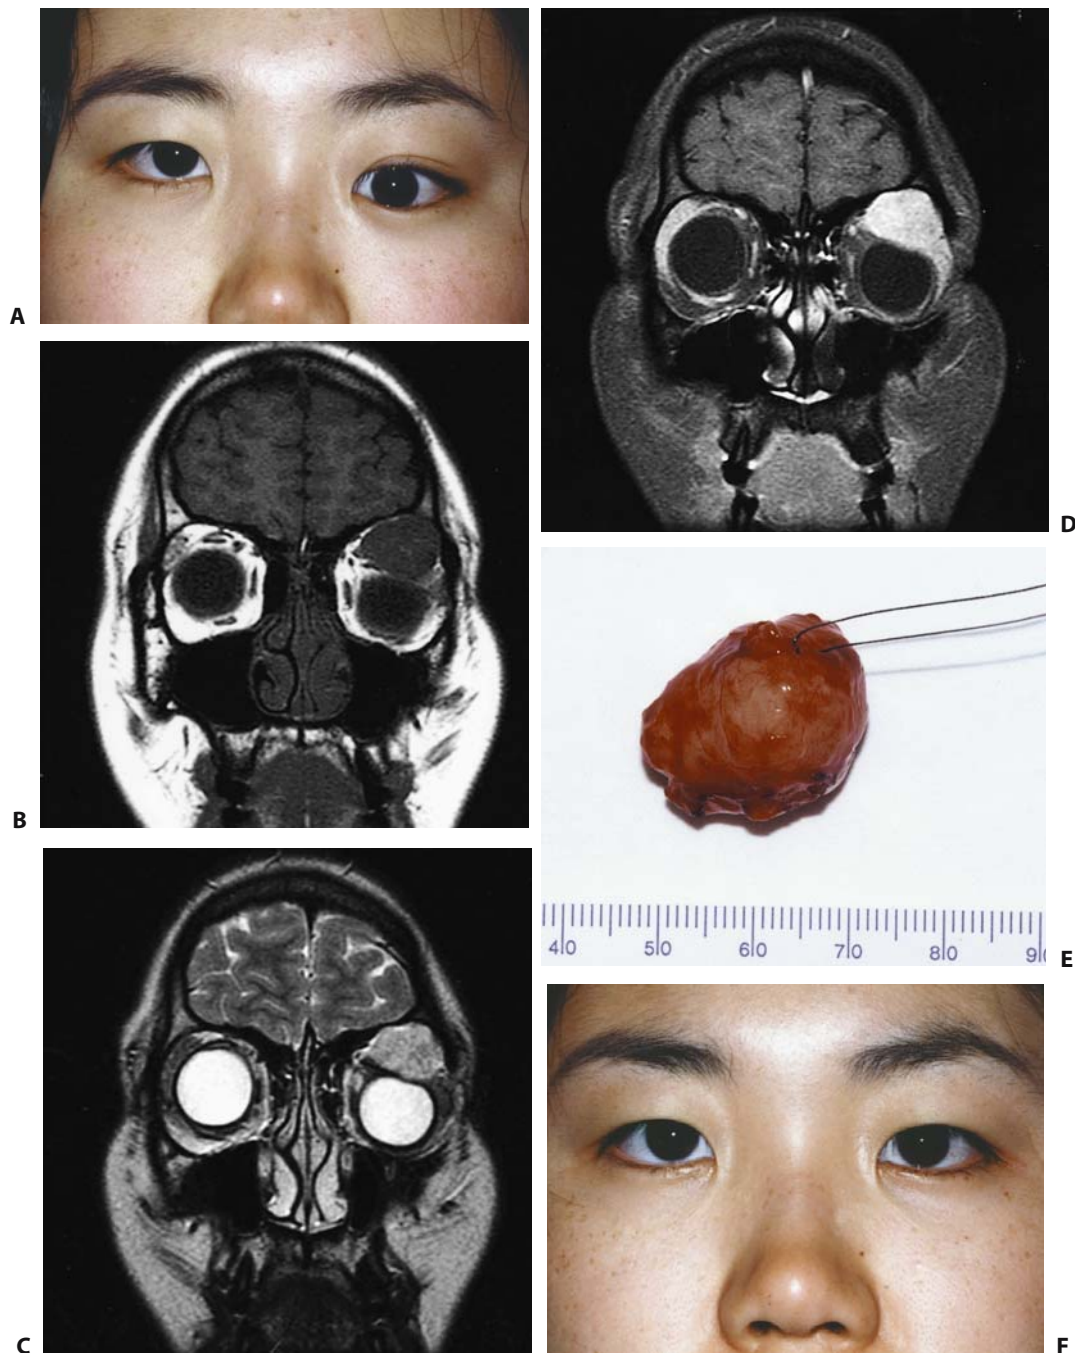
Pleomorphic adenoma in a 19-year-old woman who presented with slowly progressive proptosis and had experienced downward displacement of the left eye for 3 years. (A) Facial photograph. (B) T1-weighted coronal image shows well-demarcated lacrimal gland mass of low signal intensity with pressure erosion of the superior orbital wall. (C) T2-weighted coronal image shows
